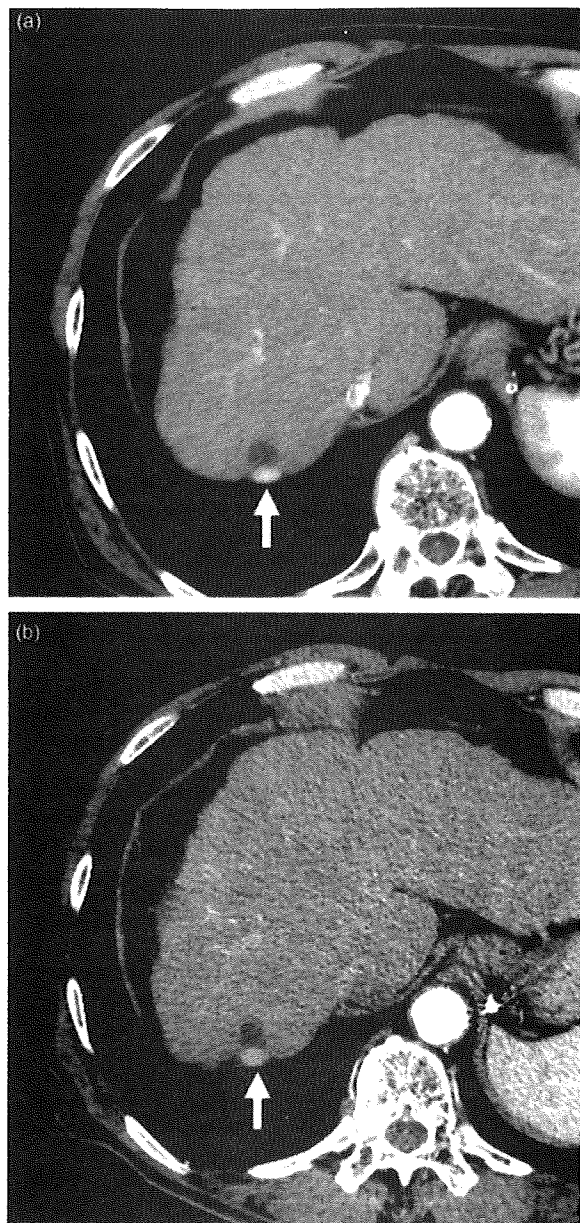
Sixty-eight-year-old male, liver cirrhosis caused by alcohol abuse. (a) Contrast-enhanced computed tomography (CT) image on 10 March 2007. Contrast-enhanced CT image showed a hypervascular lesion (arrow) considered to be recurrence of hepatocellular carcinoma around the treated area. This lesion was not demonstrated by either non-contrast ultrasound (US) or contrast-enhanced US. (b) Contrast-enhanced CT image on 22 February 2008. Hypervascular lesion (arrow) did not show remarkable changes in form and size in comparison with that in the previous CT image. This hypervascular lesion was considered to be a vascular abnormality such as arteriportal communication.
